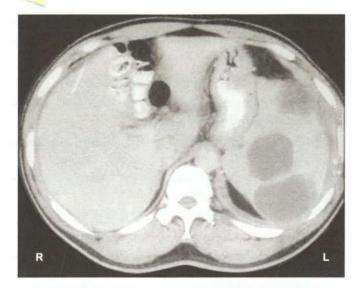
CT scan showing multiple splenic abscesses
